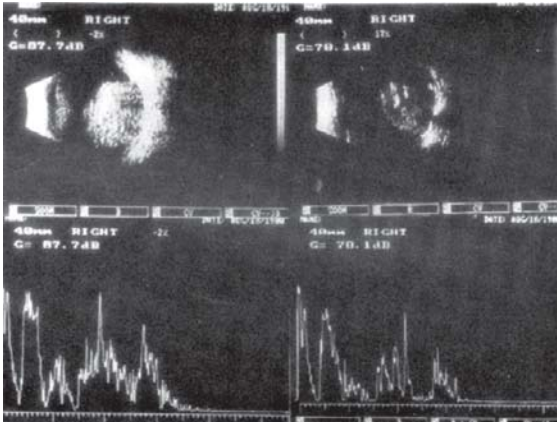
B-scan ultrasonography showing an irregularly large echogenic mass in vitreous arising from retina (Courtesy: Dr TP Das, LVPEI, Hyderabad)
